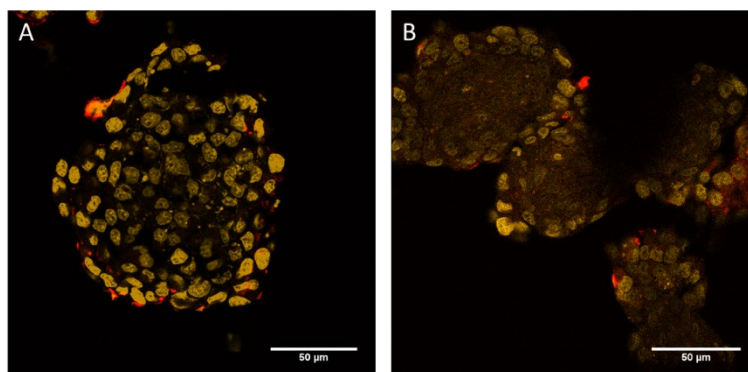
Doxorubicin release from patches of (A) thermosensitive DOX-liposomes coupled onto microbubbles and exposed to ultrasound and (B) regular DOX-liposomes coupled onto microbubbles and exposed to ultrasound. Confocal images of 10
